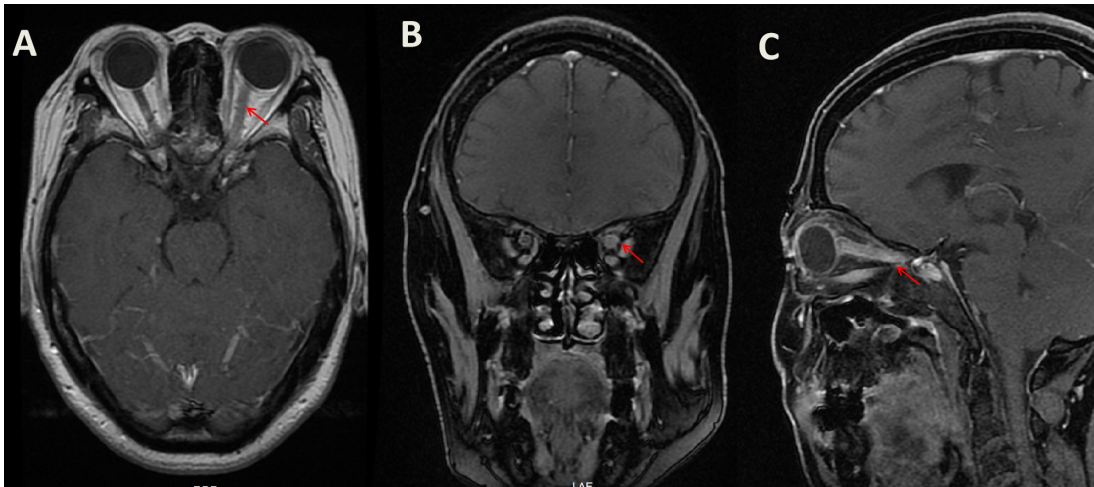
Contrast-enhanced T1-weighted images demonstrating enhancement and swelling of the left optic nerve (A,B,C).
